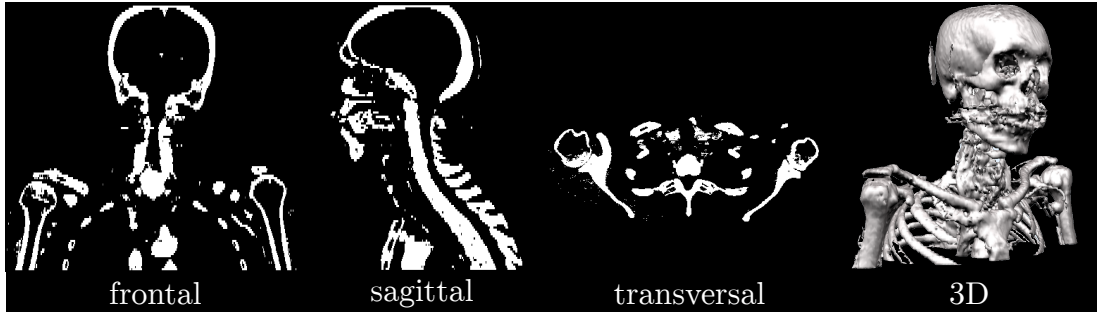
Binary target image for CT-CT registration. The fraction CT is threshold in the range $[120, 2000]$ HU to generate a binary target image. The 3D rendering shows the artifacts that are visible from the mandible and remaining artifacts from the table and positioning device.
